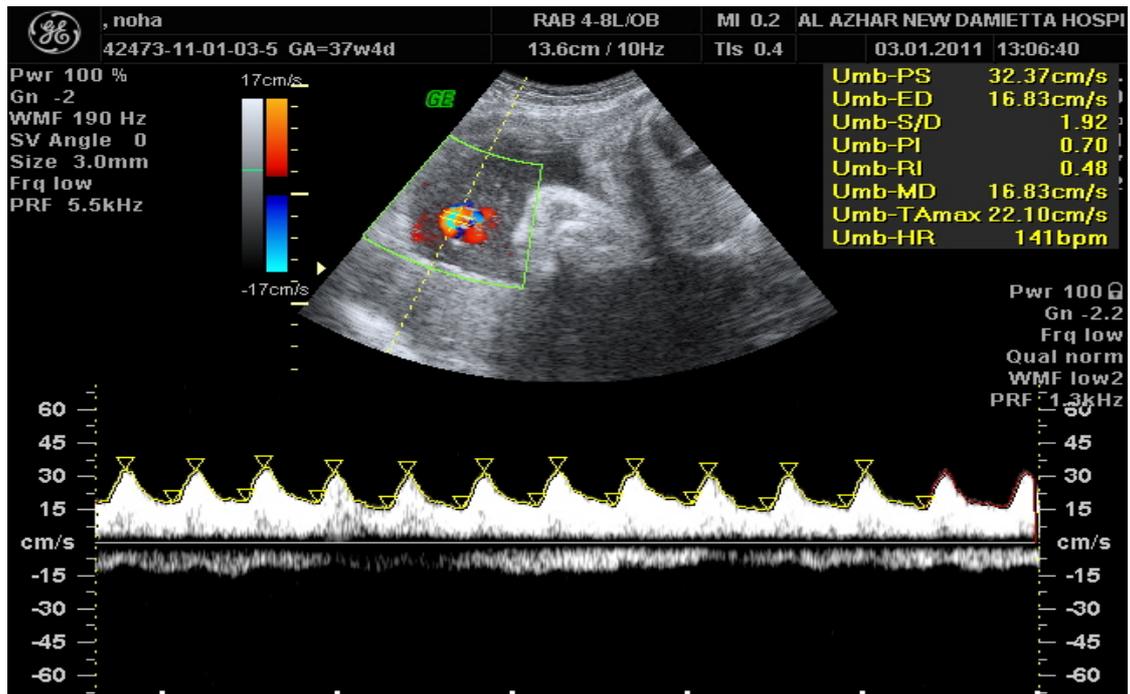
Doppler velocimetry of umbilical artery at 37weeks±4d
